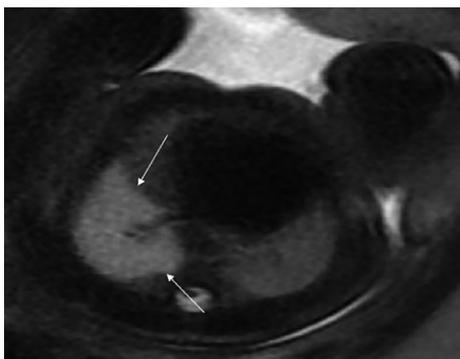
MR image at 33 gestational weeks revealed overexpanded lung parenchyma (arrows) and confirmed the diagnosis of CLE
